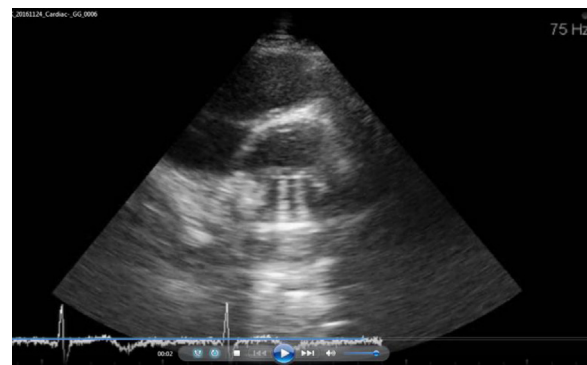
After thrombolytic therapy of patient shown in Fig. 1, TTE parasternal short axis view showed both leaflets of mitral PV in open position during diastole.
